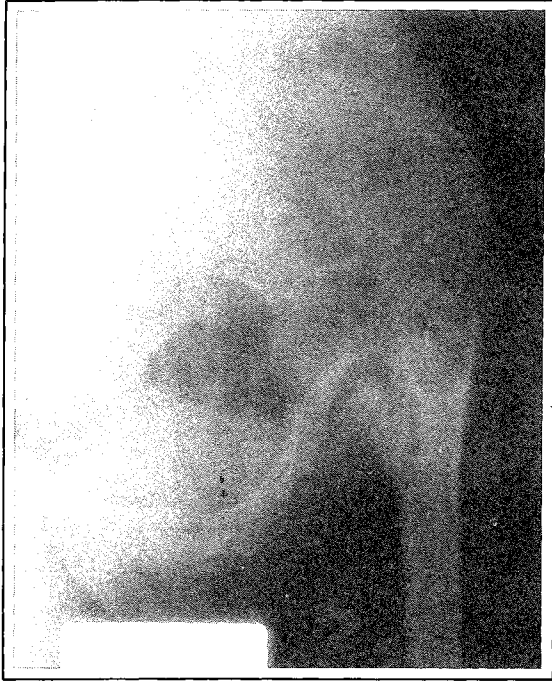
A pre-operative radiograph of Case 1, left hip joint showing marked coxa vara, a vertical pseudoarthrosis and beak shaped high riding trochanter.
